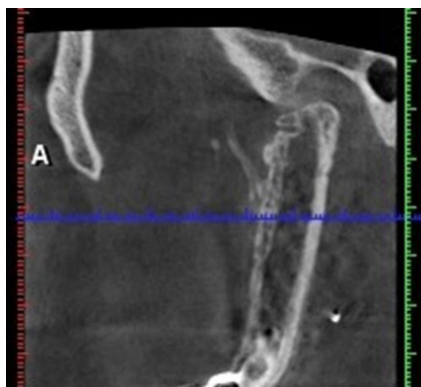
Radiographic detail of the reconstructed left condylar area, showing the blunt morphology acquired by the fibula and resembling a functional condyle.
